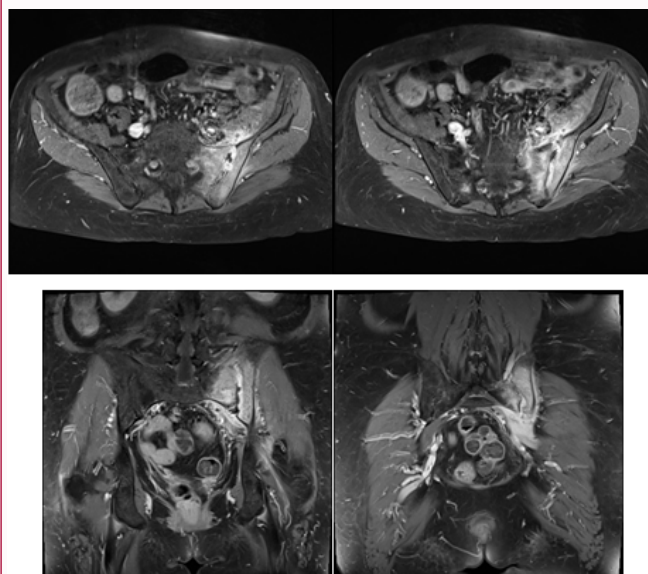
MRI revealed the presence of a lesional process centered on the left sacroiliac, with hypersignal in the sacroiliac joint, pseudo-enlargement, and bone erosions, particularly in the iliac side.
